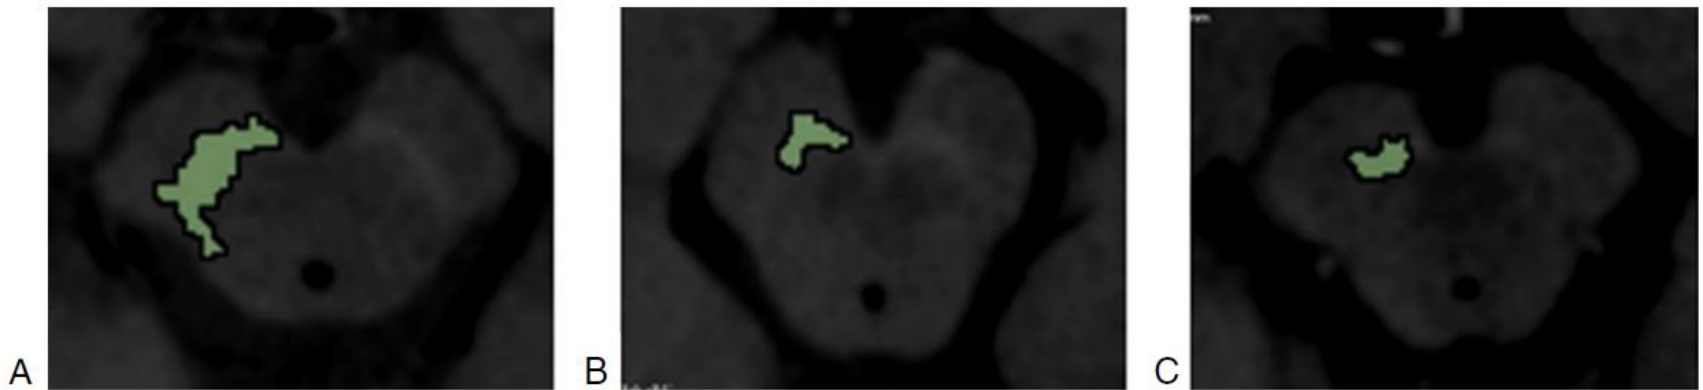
Neuromelanin (NM) area selection on NM-sensitive MRI of the SN of a healthy control (A), a de novo PD patient (B) and a LSPD (C) patient.
